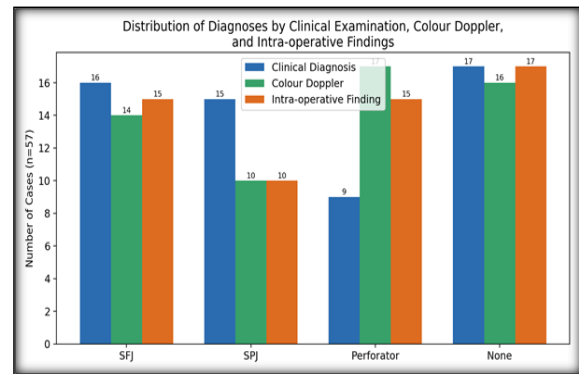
Distribution of diagnoses by clinical examination, colour Doppler, and intra-operative findings
